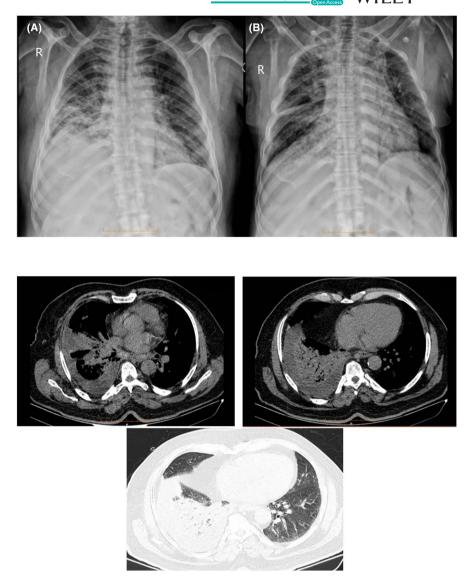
A lung and mediastinal computed tomography scan shows consolidation and patchy ground-glass opacity of the right lobe. In addition, air bronchogram and peribronchial cuffing along with moderate right pleural effusion were observed.
